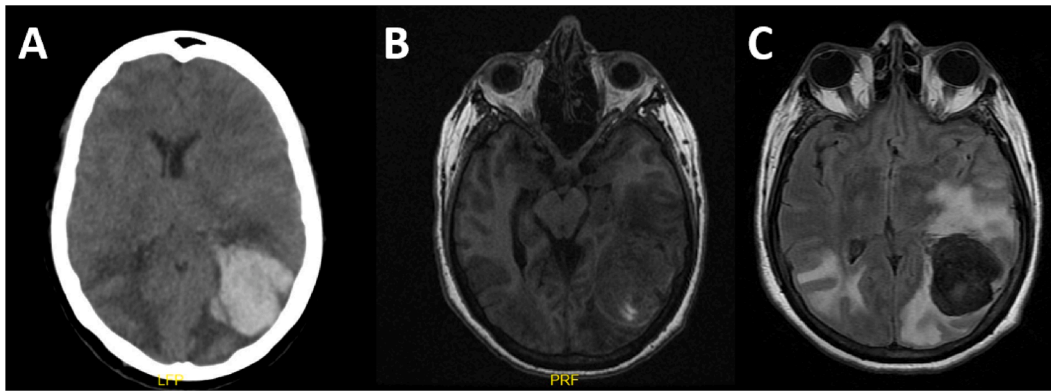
Case 2. Brain images showing an intracerebral hemorrhage in the left parietal lobe measuring $4.6 \times 4.3 \times 3.6$ cm, perilesional edema and mass effect with 7.5 mm midline shift (A: Simple brain CT scan, B: T1 sequence MRI, C: T2-FLAIR sequence).
